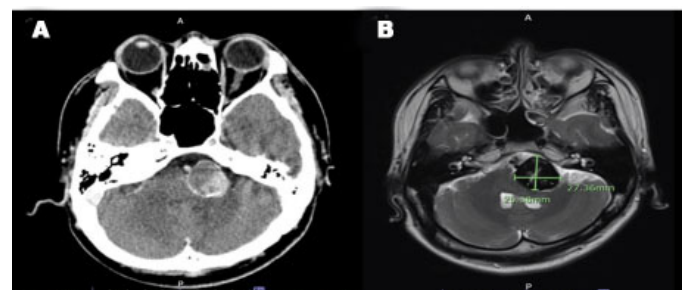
(A) contrast-enhanced preoperative CT brain scan show an unruptured giant mid-basilar aneurysm and (B) postoperative MRI brain axial view shows a 2.5 × 2.7 × 3.5-cm thrombosed basilar aneurysm after surgery and dual antiplatelet therapy.
